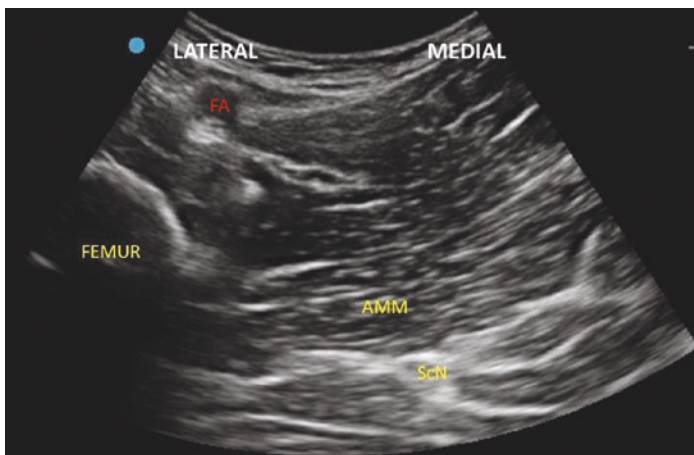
Sciatic nerve (anterior approach) ultrasound. Femoral Artery (FA), Adductor magnus muscle (AMM), Sciatic Nerve (ScN)
